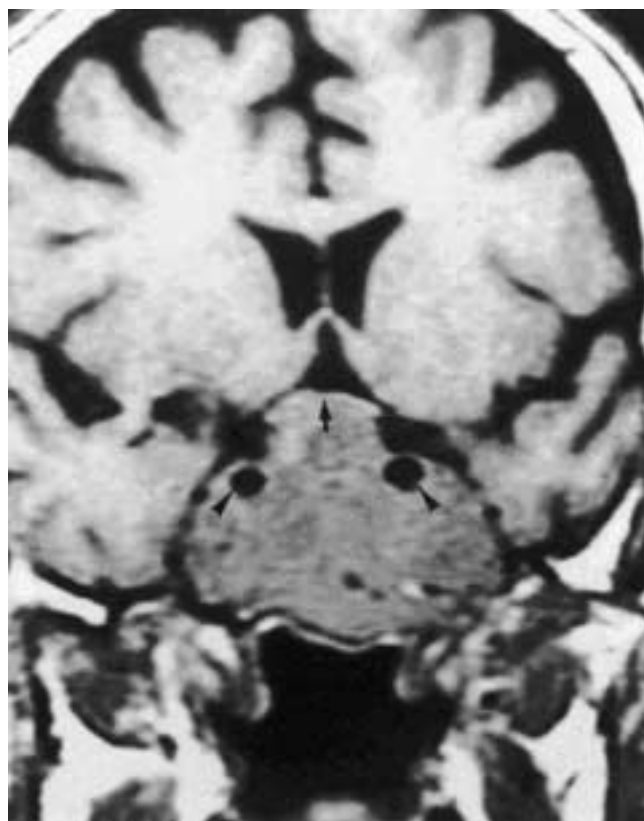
Pituitary adenoma. Coronal T1-weighted image shows a large pituitary adenoma elevating and compressing the optic chiasm (*arrow*). Both cavernous sinuses are invaded, and the tumor has extended lateral to the flow void of intracavernous internal carotid arteries (*arrowheads*). Note the outward convexity of the lateral margin of the cavernous sinuses.
